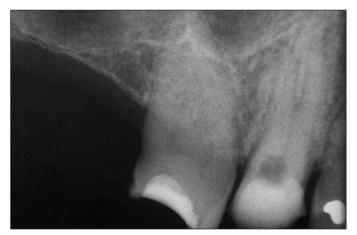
Radiographic changes range from a widening of the periodontal ligament space (note that this upper first premolar has two separate buccal roots)...
